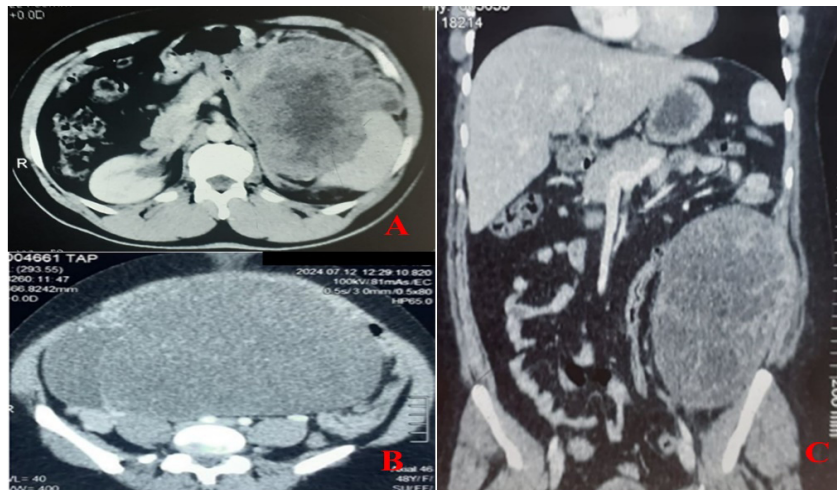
CT images showing intraperitoneal masses in axial section tissue and gastric fluid in intimate contact with the spleen without a separation line (A) and cystic (B); retroperitoneal tissue mass in coronal section (C).
